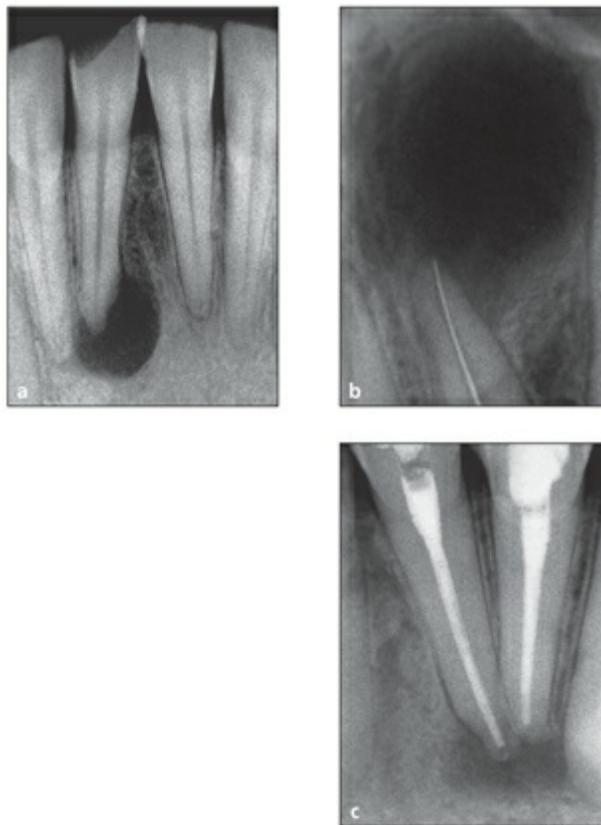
Radiographs showing presentation of each of the different types of endodontic infection (see Box 10-1): (a) primary infection; (b) persistent infection (root canal filling stage); (c) persistent/secondary infection (endodontically treated teeth).
